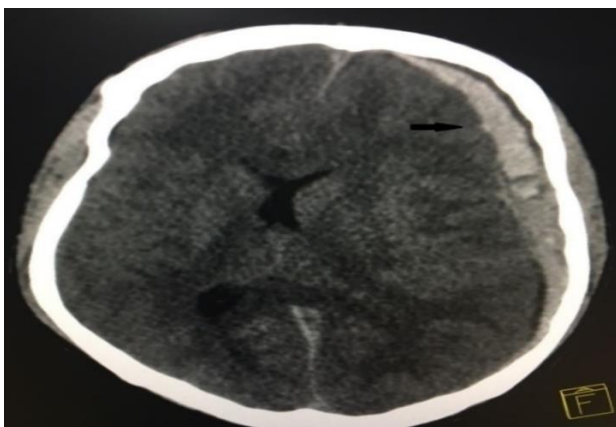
Computed tomography brain showing crescentic hyperdensity along the surface of left cerebral hemisphere with cerebral edema and midline shift marked with arrow suggestive of left subdural hematoma.
